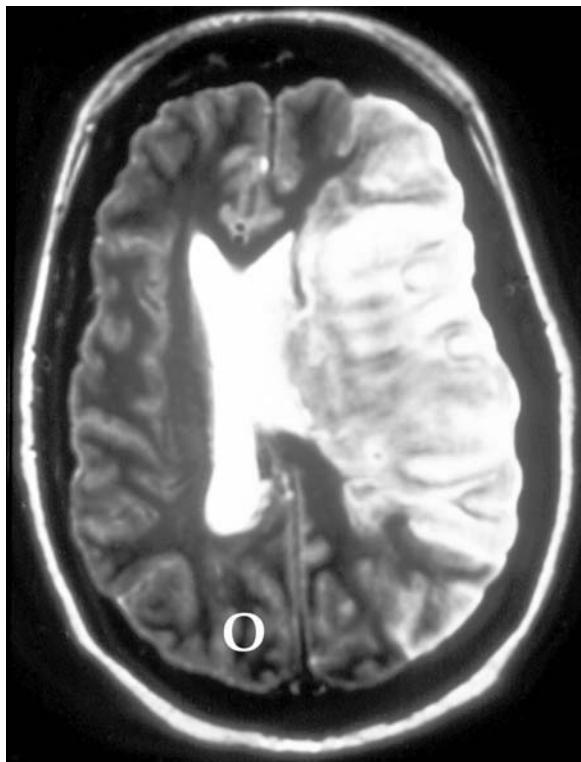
A massive acute infarction (*white mottled region*) is seen in a T2-weighted MRI scan taken through the horizontal plane. This infarction involves a branch of the left middle cerebral artery and has destroyed a portion of the frontal and parietal lobes. Edema has pushed part of the left lateral ventricle across the midline. O, occipital lobe.
